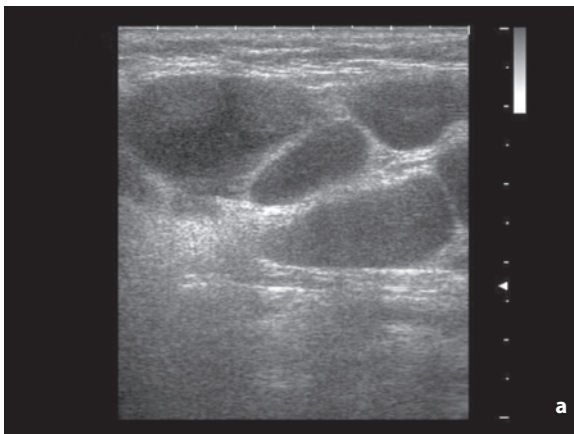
b Adenosis of the breast, study with spacer. With the same Doppler frequency (7.1 MHz) and the same focal zone, the scan without spacer pad (a) is unable to capture the color signals which are instead visible with the spacer (b). Patient with prosthesis
